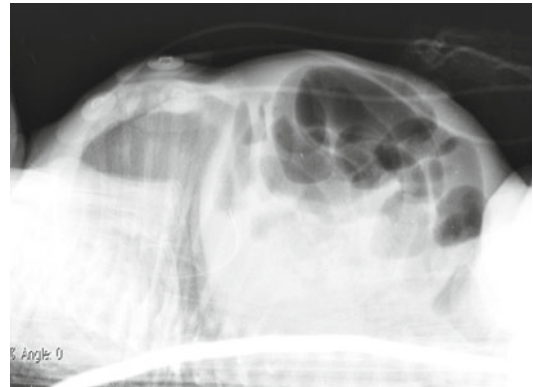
Cross-table abdominal plain film in newborn with NEC shows the condition of intestinal bowel occlusion with air fluid levels in the distended bowel loops
